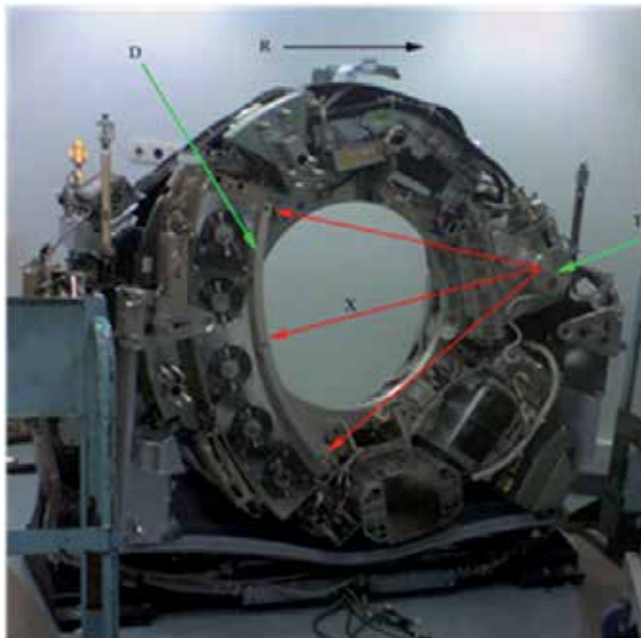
Third generation “fan-beam” CT scanner.
